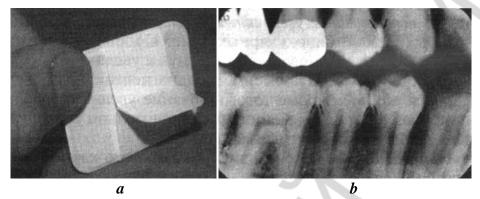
Bite-wing radiographs for assessing the condition of the crown of the tooth, with previously inserted fillings, etc.:
